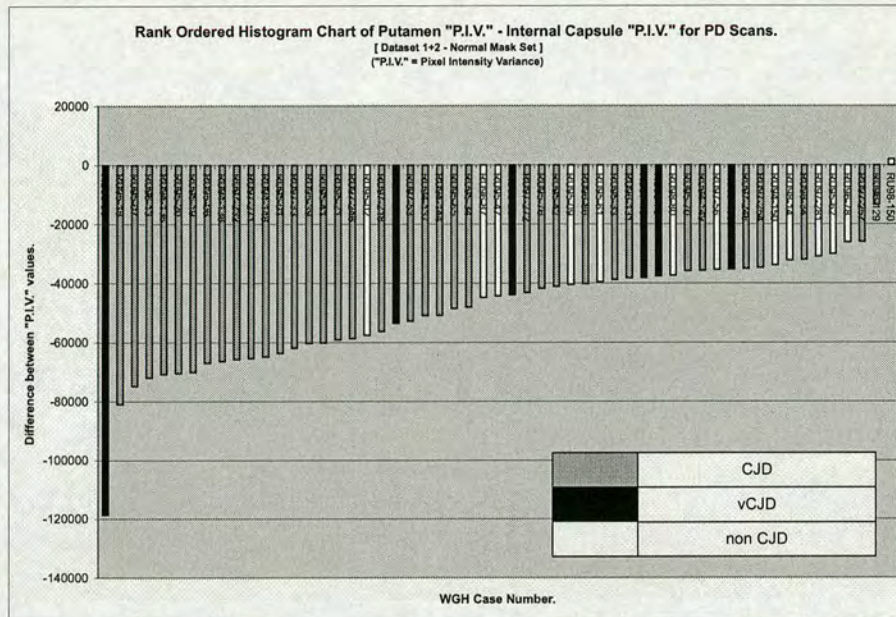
Bilateral Symmetry Tests: Rank ordered histogram of the difference between the Putamen "P.I.V." and the Internal Capsule "P.I.V." for the PD weighted MRI scan-data from the combined data-sets 1 & 2 generated using the normal (left-side+rightside) mask image-set.
